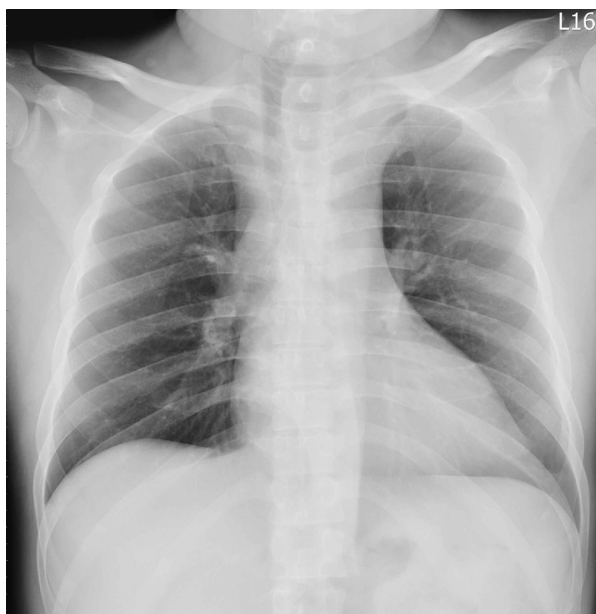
Chest X-ray showed a widened mediastinum and right deviation of the trachea.
